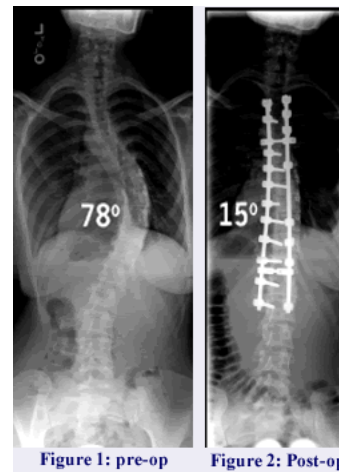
Pre and post-surgery X-Rays. Source: <http://www.scoliosis.org/forum/showthread.php?4254-Live-Broadcast-of-Scoliosis-Surgery>
